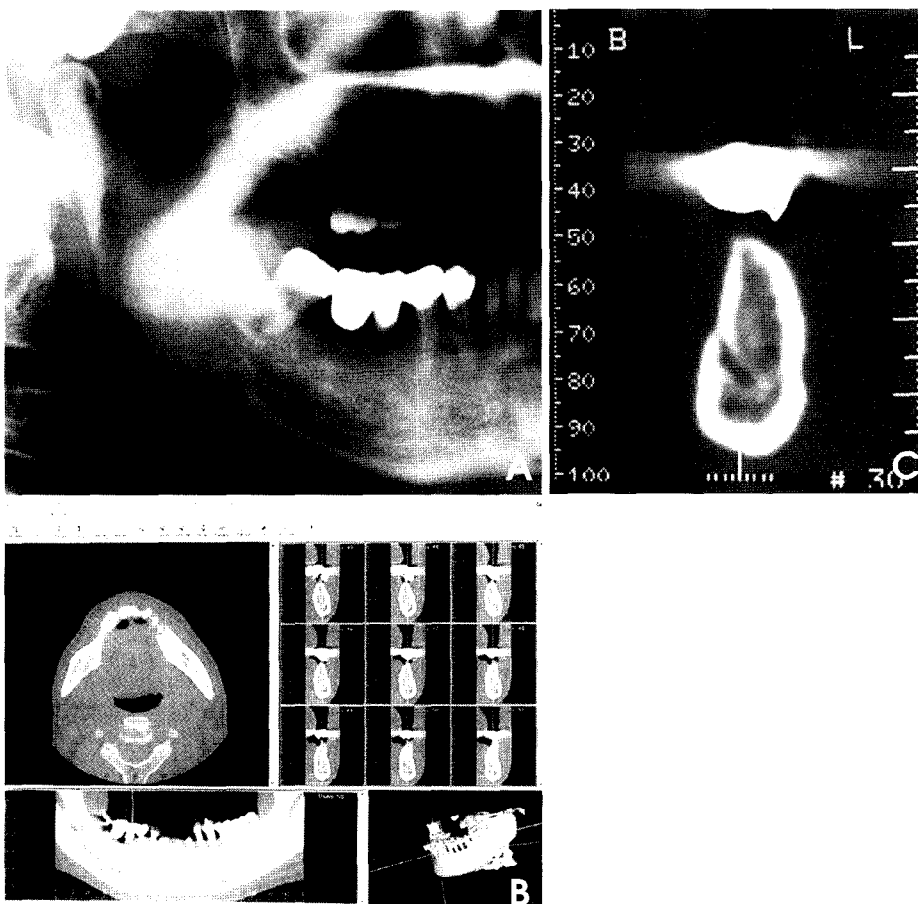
Different radiographic images of the same patient. Conventional panoramic image (A) shows indistinct image of mandibular canal at mental foramen and 1 cm posterior to mental foramen, whereas Vimplant MPR-CT panorama, paraxial images (B) and DentaScan MPR-CT images (C) show excellent clear image of mandibular canal.
